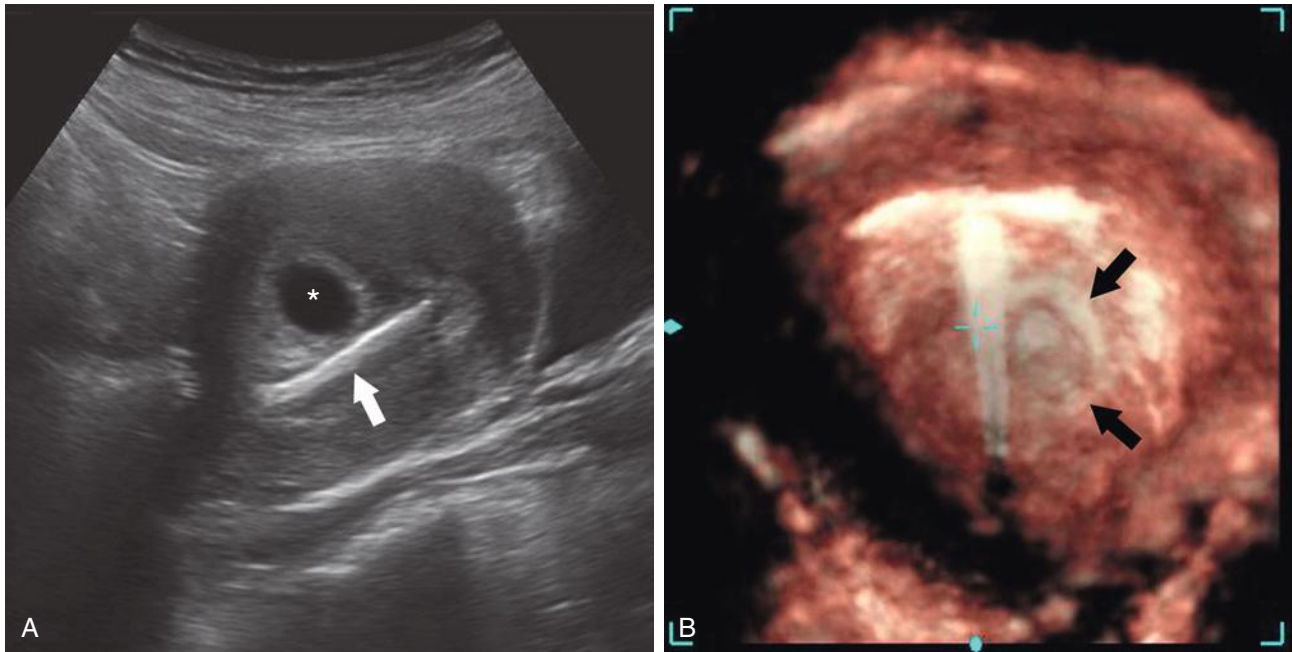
Intrauterine device (IUD) and intrauterine pregnancy. A, Longitudinal transabdominal ultrasound image shows linear echogenic IUD stem (*arrow*) directly adjacent to an intrauterine fluid collection (*asterisk*), representing an early gestational sac. B, Three-dimensional coronal ultrasound image better delineates the relationship and relative position of the T-shaped IUD to the intrauterine gestational sac (*arrows*).
